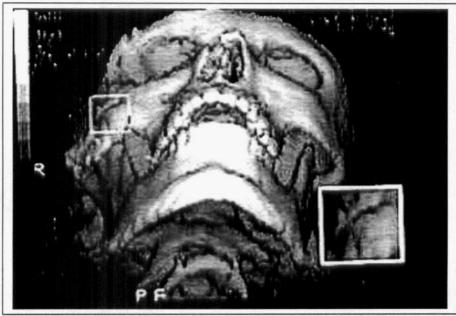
3-D CT reconstruction of facial bones in antero-inferior view
